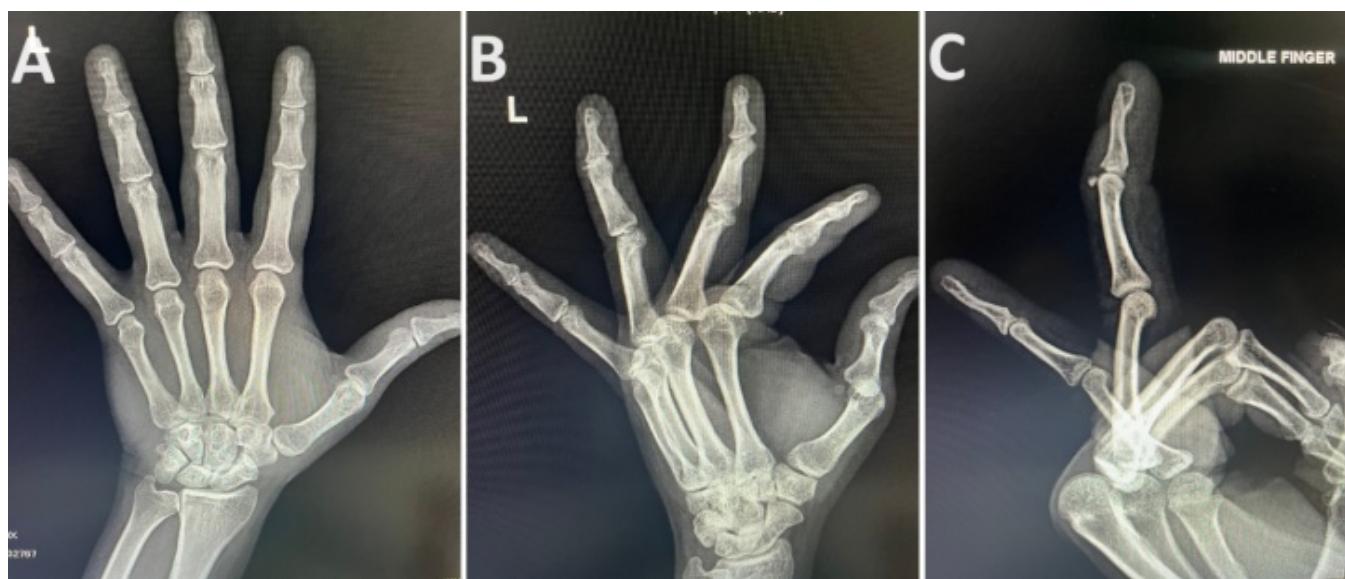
Radiographs demonstrating how a phalanx pathology can be easily missed in radiographs if only hand radiographs with anteroposterior (AP) and Oblique views are done. (a) AP and (b) Oblique radiographs of the hand of a patient who came with a history of injury to the hand with a cricket ball. The radiographs were viewed by an orthopedic surgeon, and the patient was only given analgesics and reassured. © However, when the patient returned a few days later, and a lateral view of the injured finger was done, it showed an avulsion chip fracture of the base of the distal phalanx, indicating a bony mallet finger.
